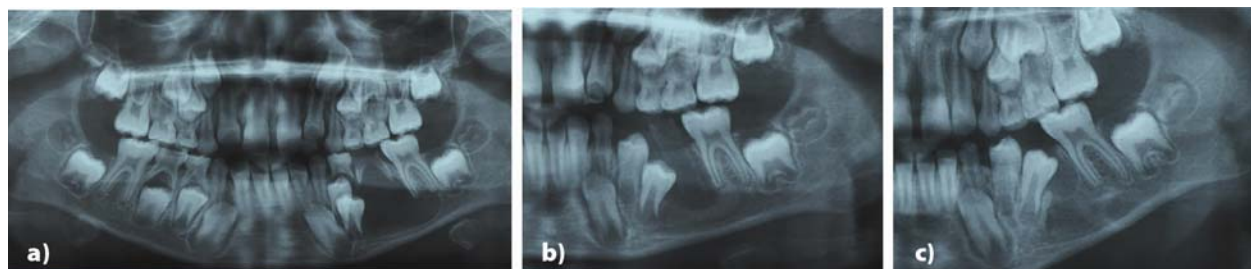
a) Panoramic radiograph shows a dentigerous cyst involving permanent premolars germs; b) After four months of decompression, radiograph view shows a polyethylene tube in the defect and newly formed bone layer with permanent premolars' germs eruption through cystic cavity; c) After nine months of decompression, a panoramic radiograph shows complete resolution of the lesion and moving the involved teeth into physiologically determined position within dental arches.
